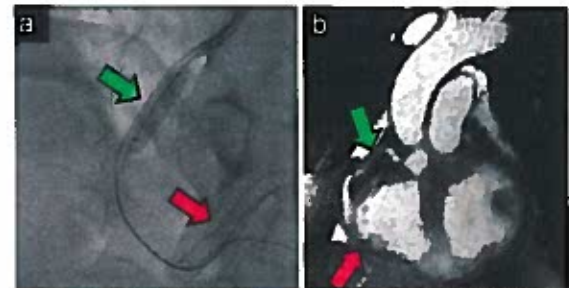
Comparison between X-ray coronary angiography (a) and 5D XD-GRASP (b) in one of the patients. The signal void in b (green and red arrows) confirms the presence of two stents in the RCA.
